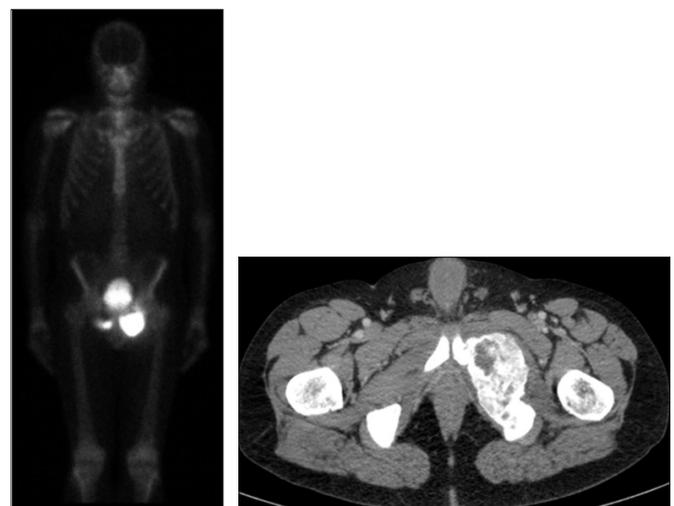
Bone scan (left) and CT (right) showing left pubic ramus recurrence.
